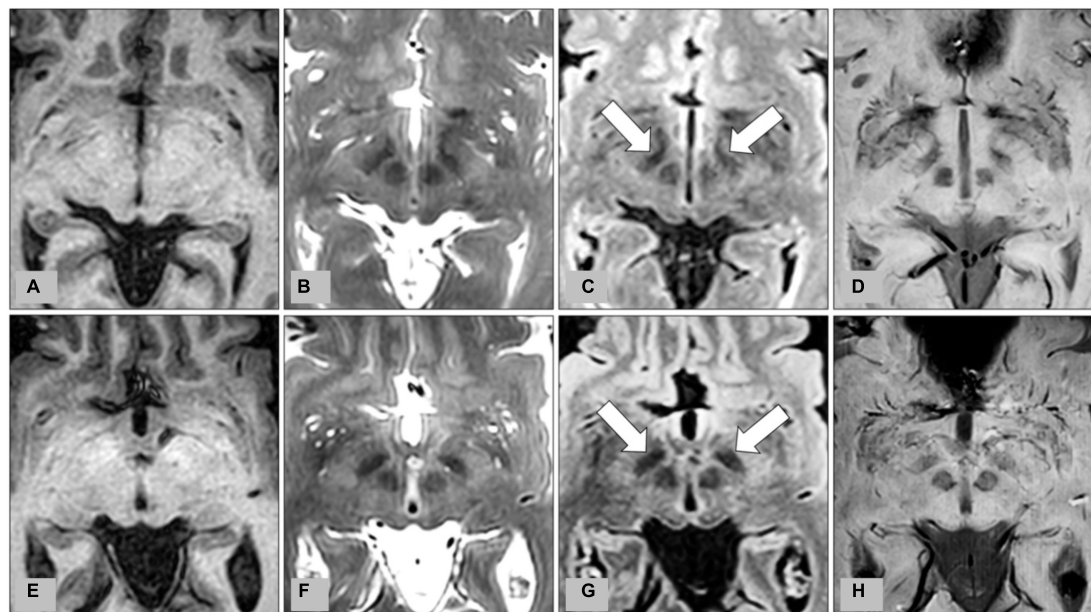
Representative images from preoperative MRI of two patients with medication-refractory Parkinson's disease at the level of the subthalamic nucleus (STN). (A) T1-weighted imaging (T1WI), (B) T2-weighted imaging (T2WI), (C) fluid-attenuated inversion recovery (FLAIR), and (D) susceptibility-weighted imaging (SWI) from MRI of a 56-year-old male patient, and corresponding (E) T1WI, (F) T2WI, (G) FLAIR, and (H) SWI from MRI of a 62-year-old male patient. Bilateral STN are indicated by arrows on FLAIR (C,G).
